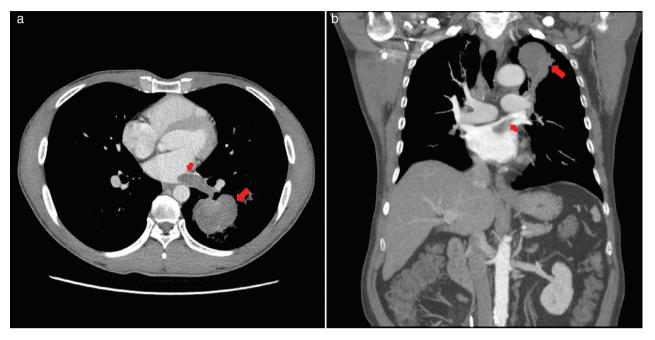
Representative chest computed tomography images of the two cases of primary lung cancer extending into the left atrium: (a) a left lower lobe tumor and (b) a left upper lobe tumor encroaching into the left atrium.
